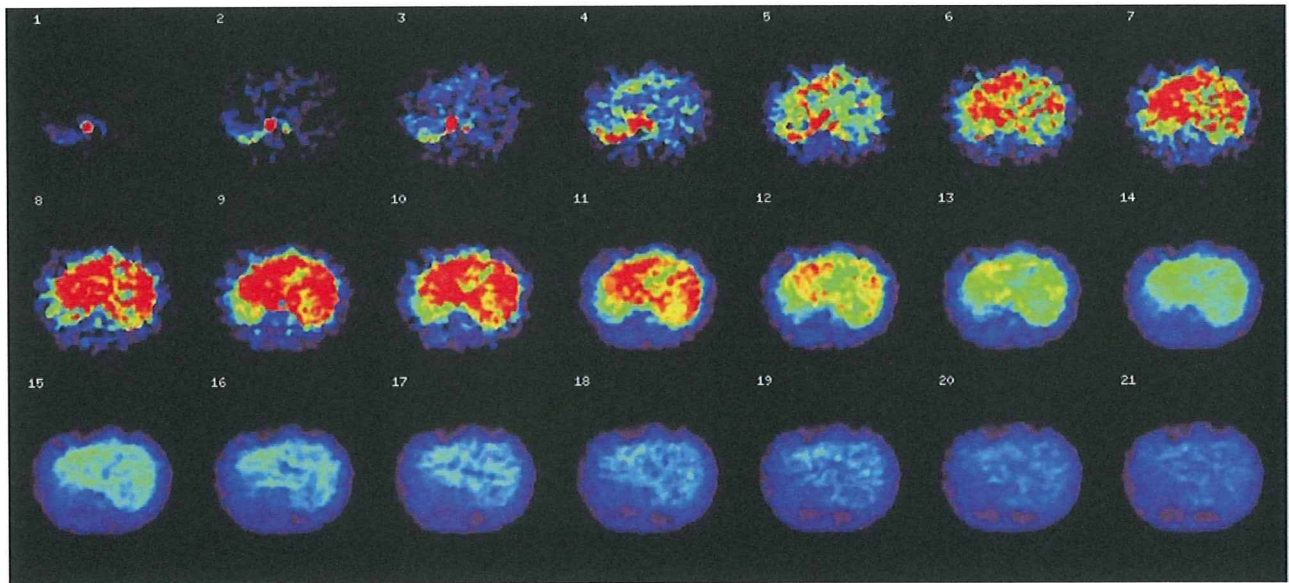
Representative view of liver [^{18}F]FDG images obtained from one of the experimental studies. Each figure is represented in the same scale and slice at the n th frame, which is indicated in the *upper left corner* of each image
